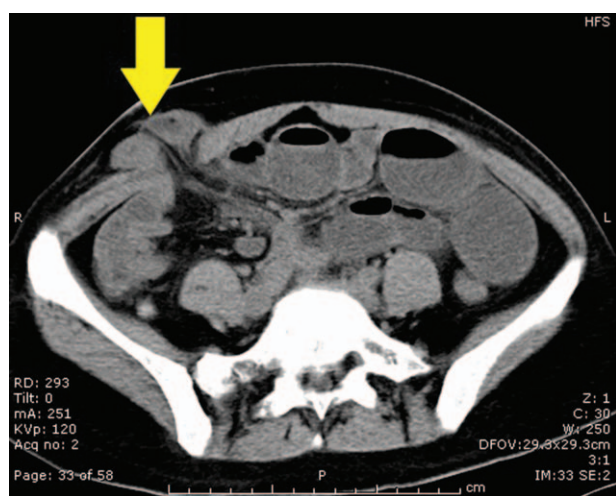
Abdominal CT scan of small bowel loops above the fascia in a patient with herniation (arrow) through a 10-mm right lateral trocar site (patient No. 3 from Table 3). CT: Computed tomography.
